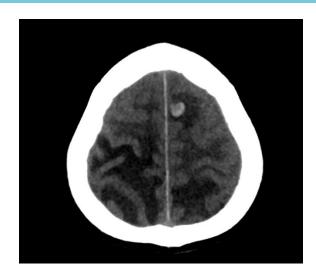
Image of initial CT brain done showing largest lesion located at left parietal lobe with significant perilesional oedema.
